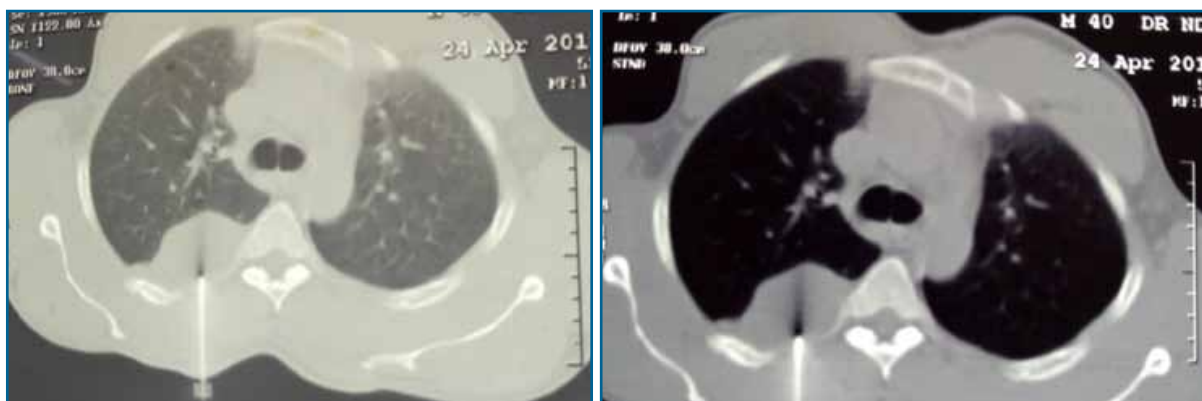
CT-guided percutaneous core biopsy of the lung
